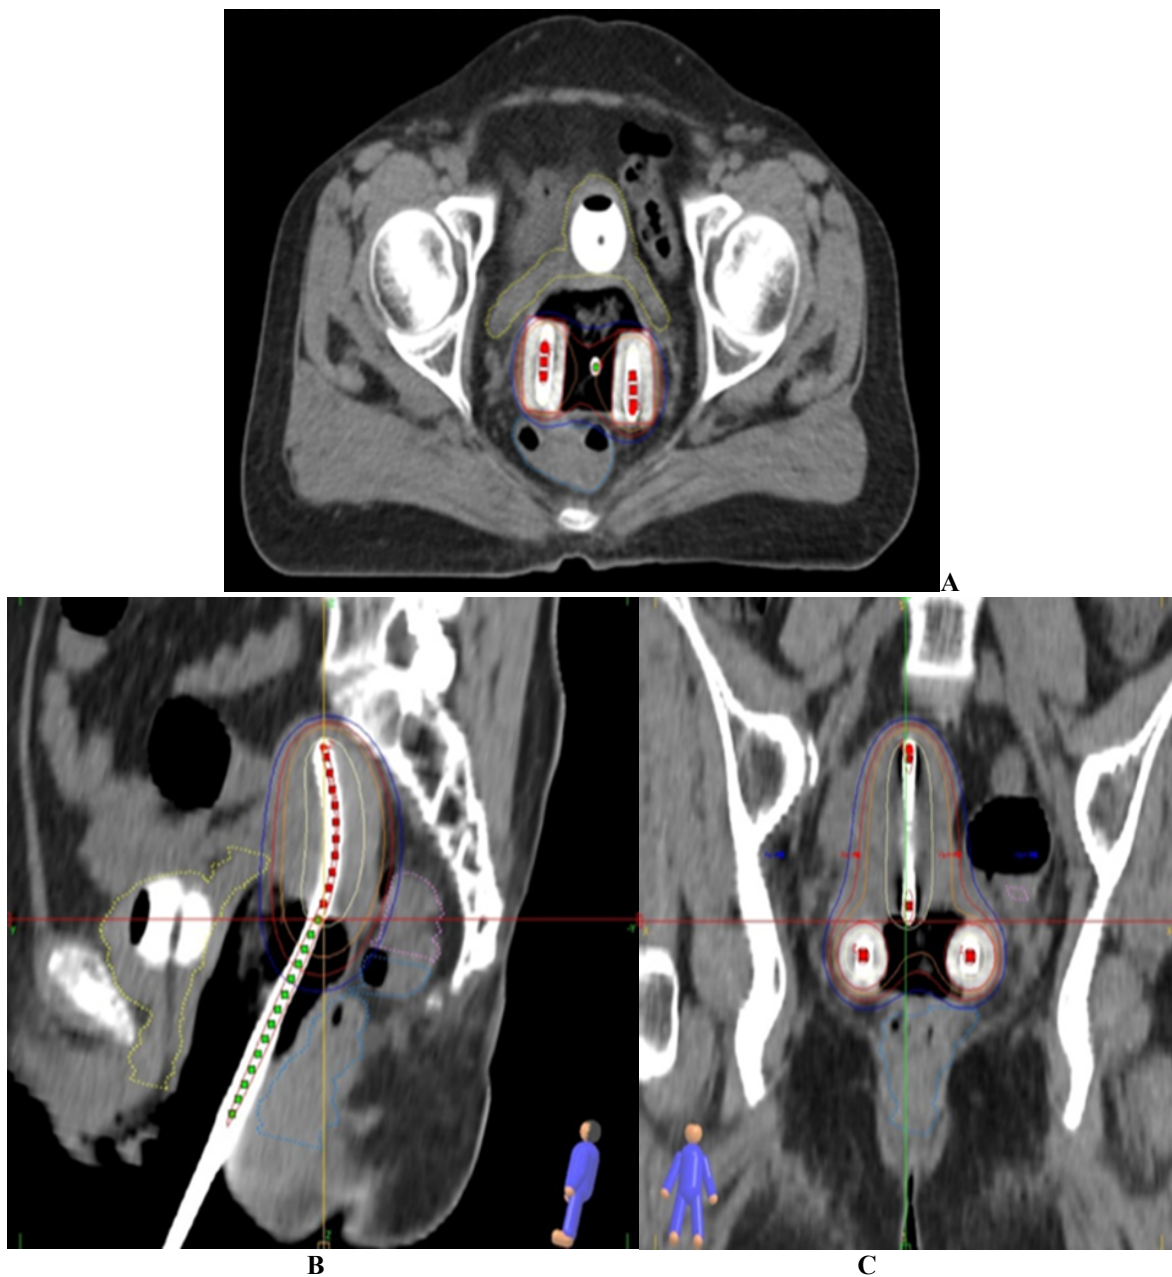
(A, B, C): Axial, Sagittal and Coronal CT images showing QAR contours and Isodose curves
